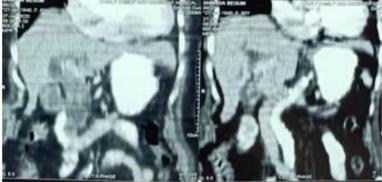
Multiaxial pre- and post-contrast CT scan suggested Neoplasm in GB and CBD with the invasion of CHD with dilatation of intra-hepatic biliary tree and also Ampulla of Vater and adjoining head of pancreas and uodenum with dilatation of MPD. Therewas also minimal right-sided pleural effusion
